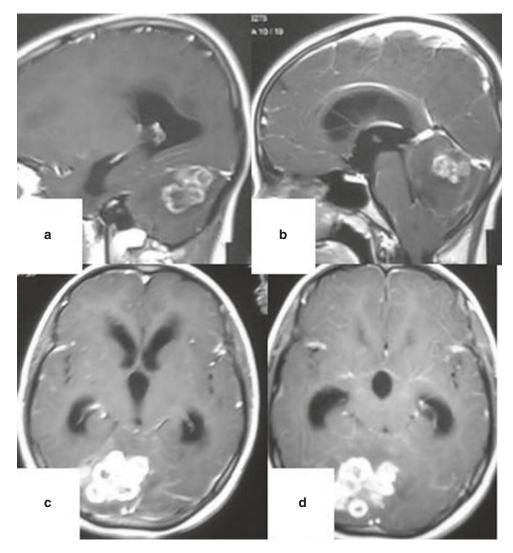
Contrast MRI of the brain; (a, b) sagittal images and (c, d) coronal images showing multiple coalescing ring lesions (tuberculomas) in the cerebellum
